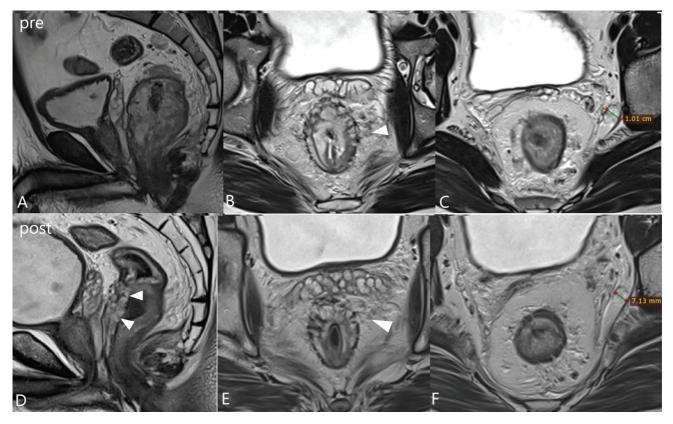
(A–C) Baseline T2 high-resolution (HR) sagittal and axial magnetic resonance imaging (MRI) shows a bulky T2 hyperintense mucinous mid-rectal cancer, extramural vascular invasion (EMVI) (arrowhead) seen as T2 hyperintense irregular expansion of the mesorectal vein and significant T2 hyperintense left lateral pelvic node or obturator node (measured in C). (D–F) MRI following total neoadjuvant treatment (TNT) shows persistent EMVI (arrowhead) and a significant (> 6 mm) mucinous left obturator node (measured in F).
